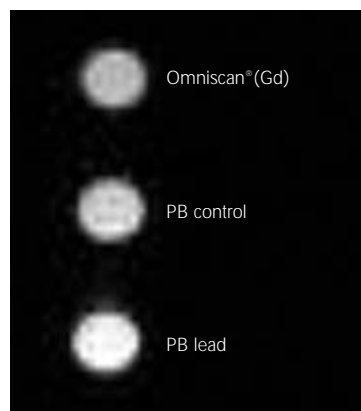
T1-weighted MR-imaging of a PhotoBiotics MRI agent compared with control samples at the same concentration. The PhotoBiotics sample produces a brighter image. The advantages here are that the scFv multiply-loaded MRI contrast agent is targetable and has potentially more favourable pharmacokinetics/dynamics compared with standard contrast agents; the OptiLink platform ensures that the individual paramagnetic entities on the scFv do not magnetically interfere with one other, thus significantly enhancing their performance.
